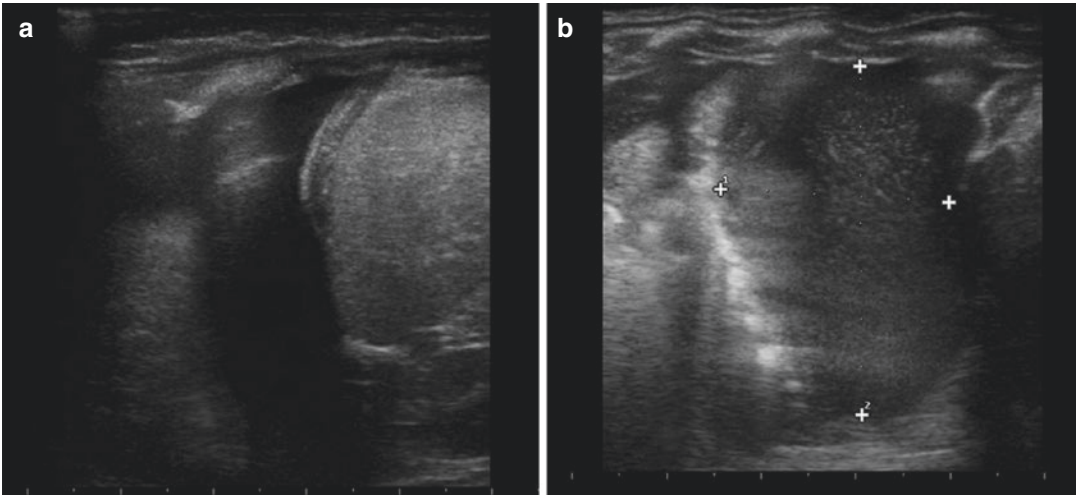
Correct acoustic windows for B-Mode thoracic US: (a) suprasternal notch; (b) parasternal region; (c) longitudinal emiclavicular line; (d) longitudinal posterior axillary; (e) axial intercostal space; (f) oblique parasternal
